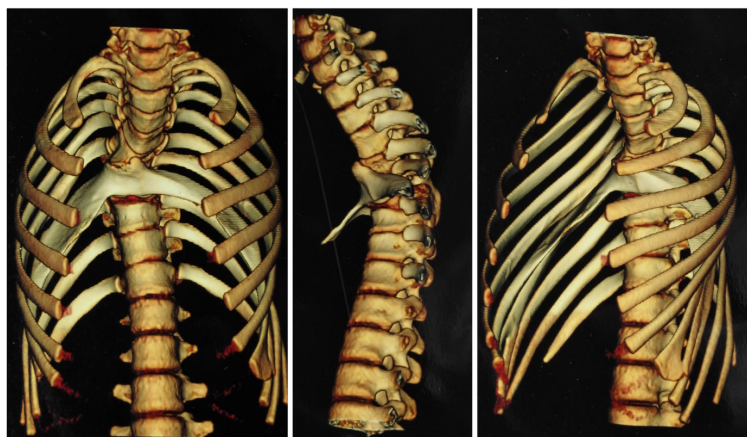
CT scan with 3D reconstruction showing bifurcated rib articulated with the anterior aspect of the T5 vertebra with kyphoscoliosis, extending toward anterior inferolaterally. The distal anomalous rib had an osseous connection with adjacent fused rib, extending bifid rib locally depressed into the thoracic cavity.
